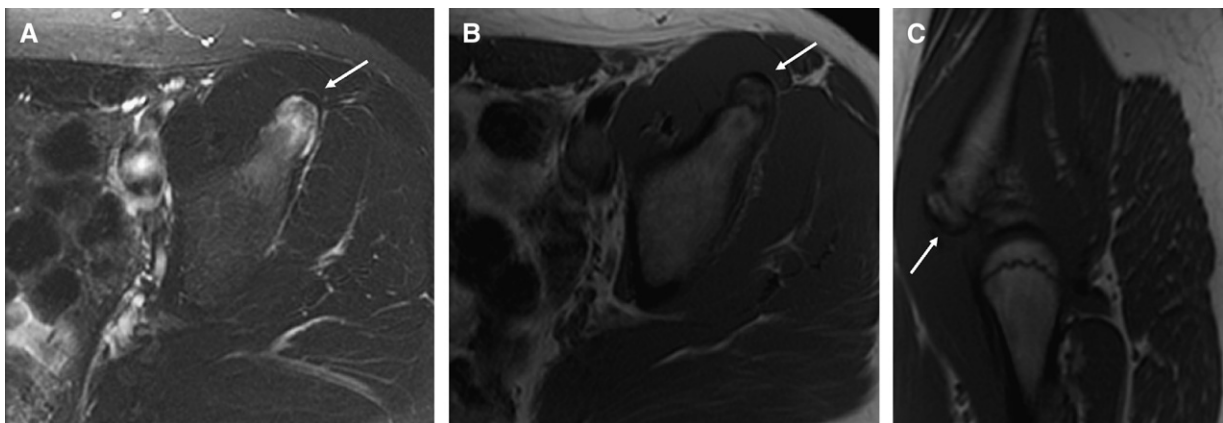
Avulsion fracture of the left anterior inferior iliac spine. (A) Axial fat-saturation fast spin-echo (FSE), T2-weighted magnetic resonance imaging (MRI), and (B, C) axial and sagittal FSE T1-weighted MRI, demonstrating avulsion fracture of the left anterior inferior iliac spine at the insertion of the rectus femoris (white arrows).
